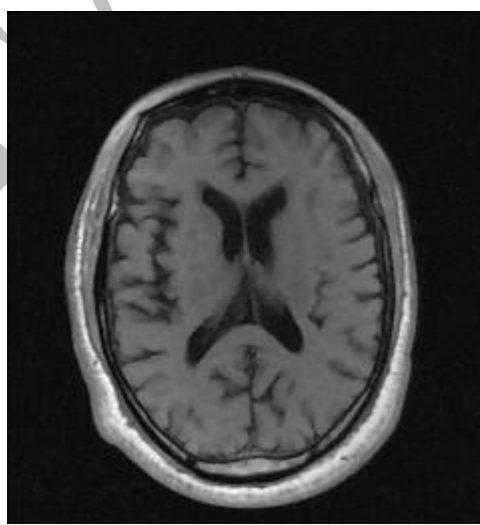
Transverse view of brain MRI showing generalised cerebral and ventriculomegaly
